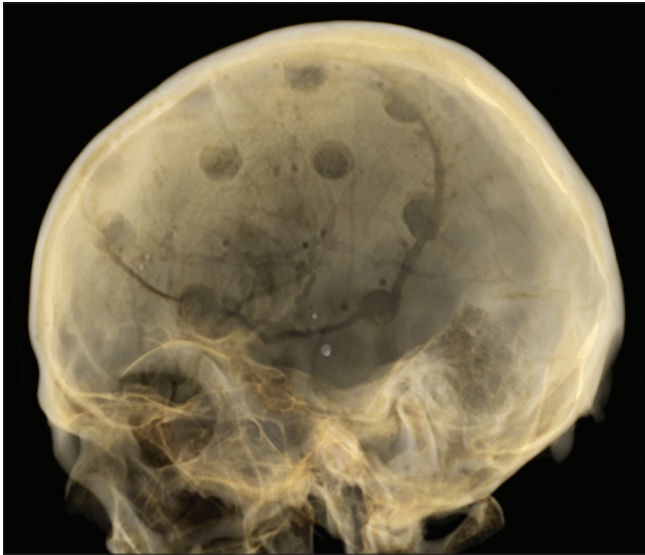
Computed tomography of the brain: Three-dimensional reformation showing previous craniectomy and burr holes
